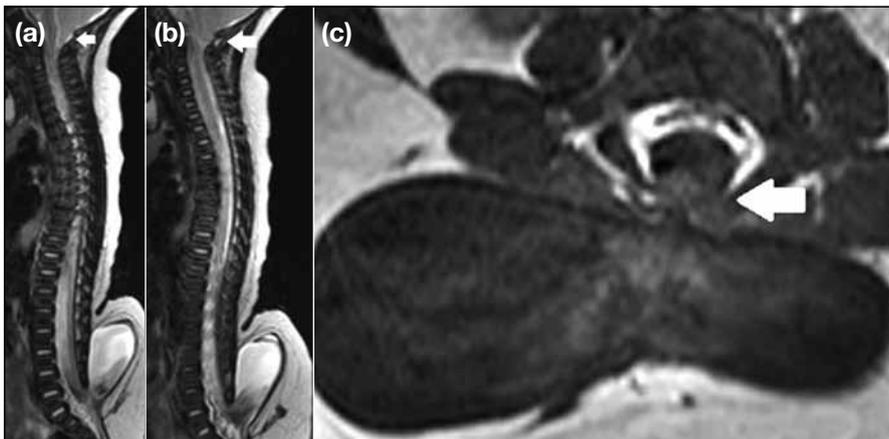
Chiari II malformation: (a, b) T2-weighted sagittal magnetic resonance (MR) images show a lumbosacral myelomeningocele and tonsillar herniation (arrows), suggestive of a Chiari II malformation. (c) A T2-weighted axial MR image demonstrates the spina bifida (arrow) and herniation of neural tissue into the myelomeningocele.
